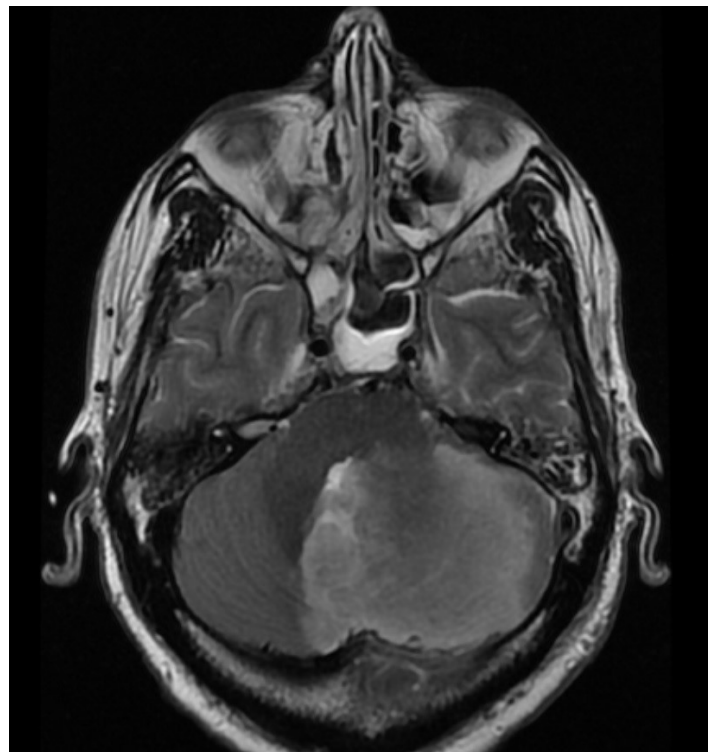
Left cerebellar infarct due to fungal emboli seen on MRI.*
